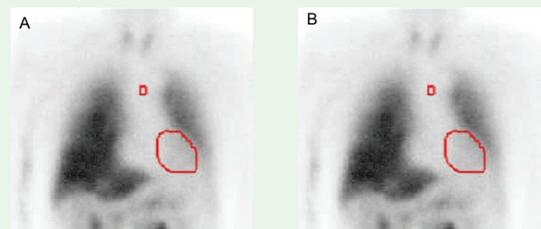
ATTRv patient with an abnormal/ positive ¹²³I-MIBG scintigraphy. A. Early HMR ratio 1,84. B. Late HMR ratio 1,34. Wash-out rate 27% (normal value <20%).
